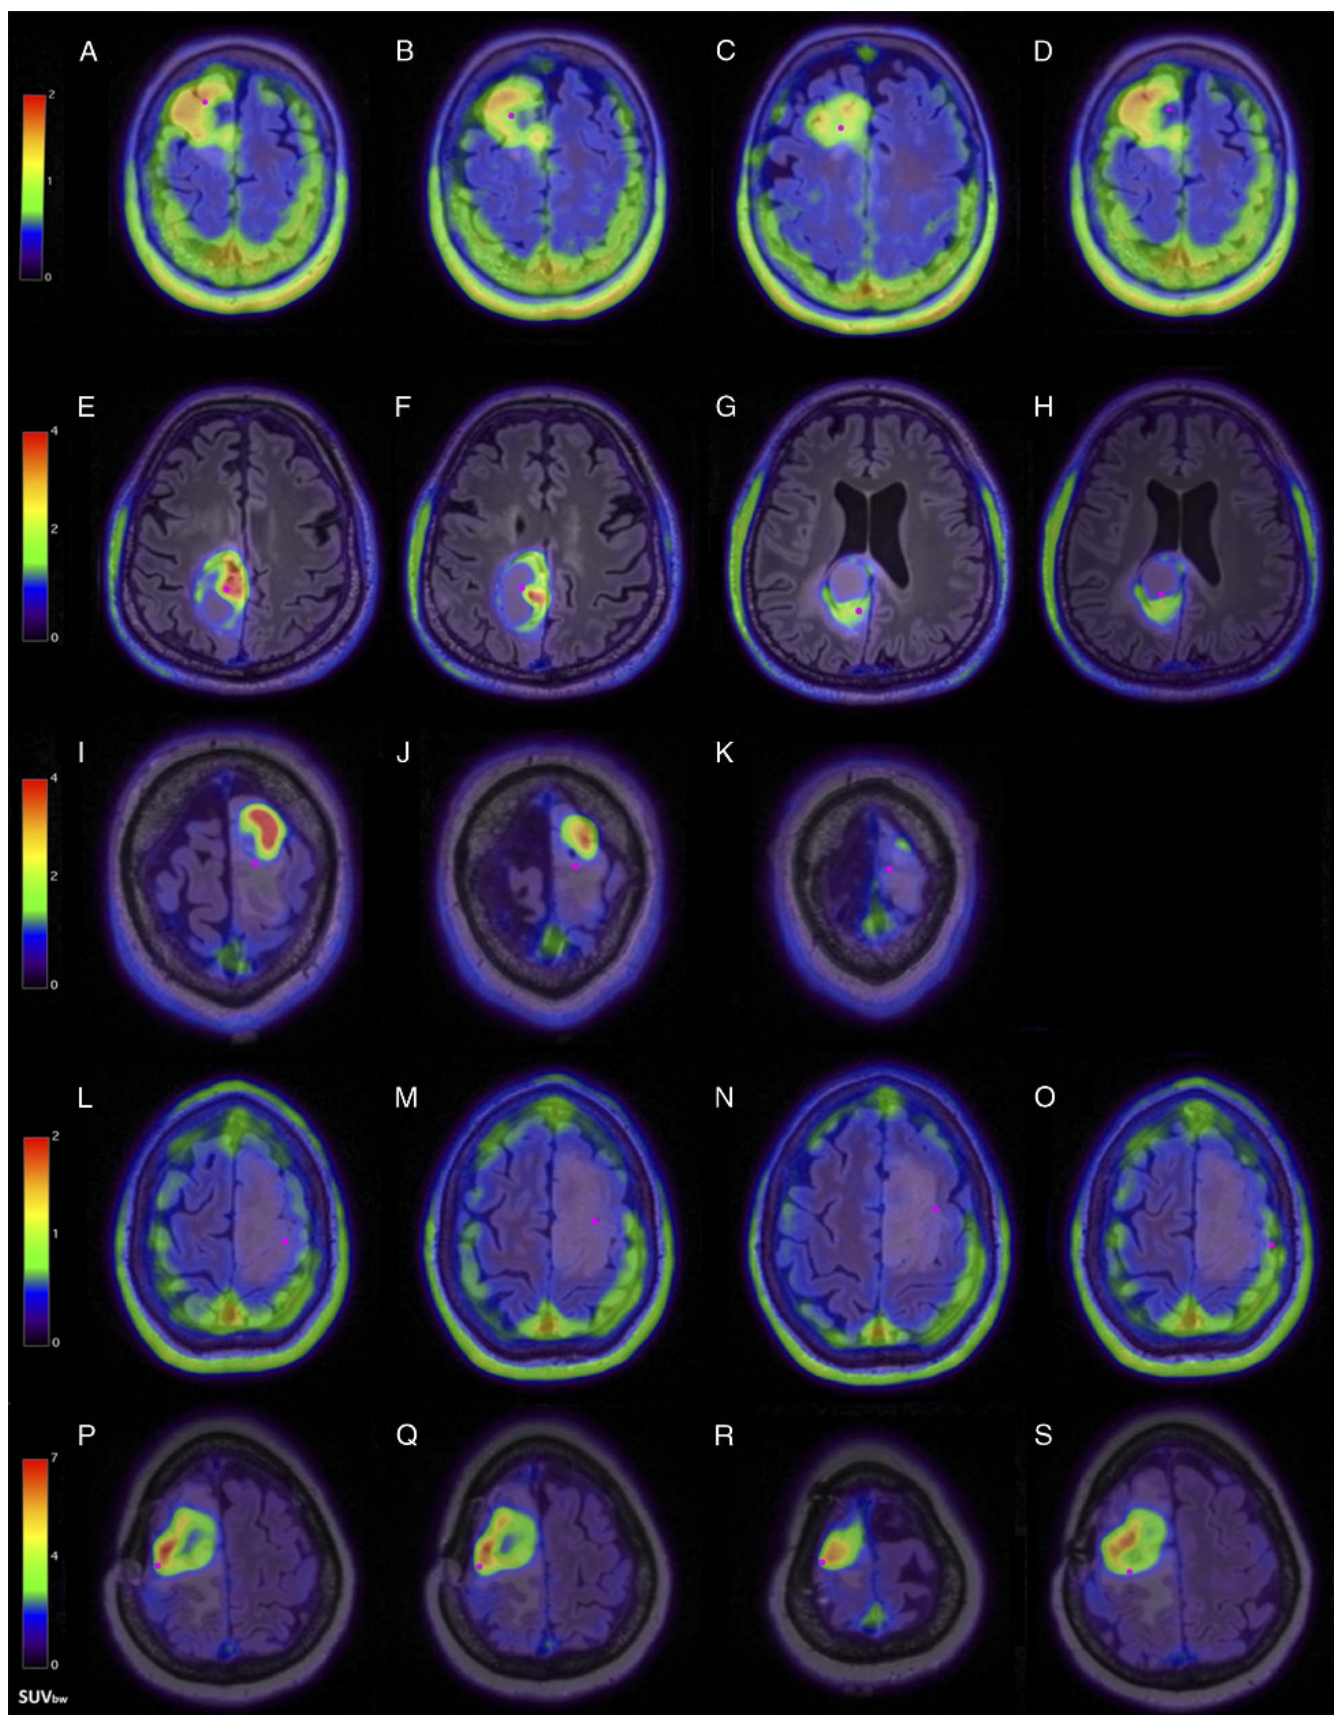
Fused PET/FLAIR images with localized biopsy sites (marked in pink) for (A–D) patient 1, (E–H) patient 2, (I–K) patient 7, (L–O) patient 8, and (P–S) patient 10.
